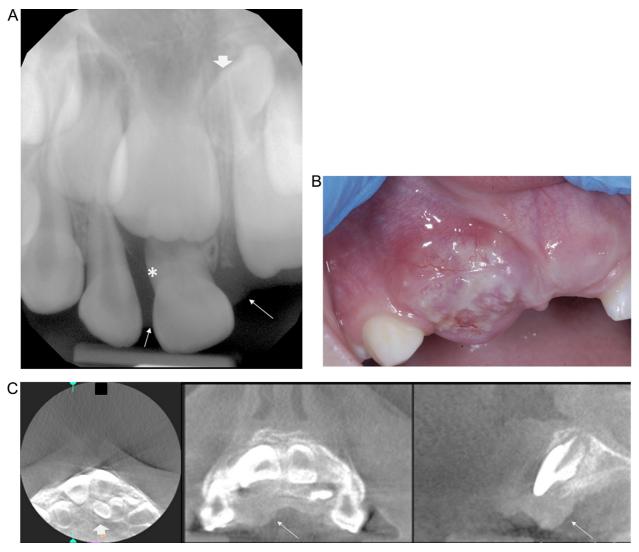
Radiographs and clinical images. A, Periapical radiograph at the initial presentation showing a radiolucency distal to the right deciduous central incisor (#E) (*), soft tissue shadow around it (*arrows*), and a mesiodens (*arrowhead*) apical to the left permanent central incisor (#8), between the roots of two permanent central incisors (#8 and #9). B, Clinical image showing a labial and palatal gingival mass at the right edentulous ridge with some whitish exudate 4 weeks after the initial presentation (see Figure 1A) and 1 week after extraction of the right deciduous central and lateral incisors (#E and #D). C, A cone beam computed tomography (CBCT) view showing significant palatal soft tissue swelling (*arrows*) and an impacted mesiodens (*arrowhead*) 4 weeks after the initial presentation (see Figure 1A) and 1 week after extraction of the right deciduous central and lateral incisors (#E and #D).
